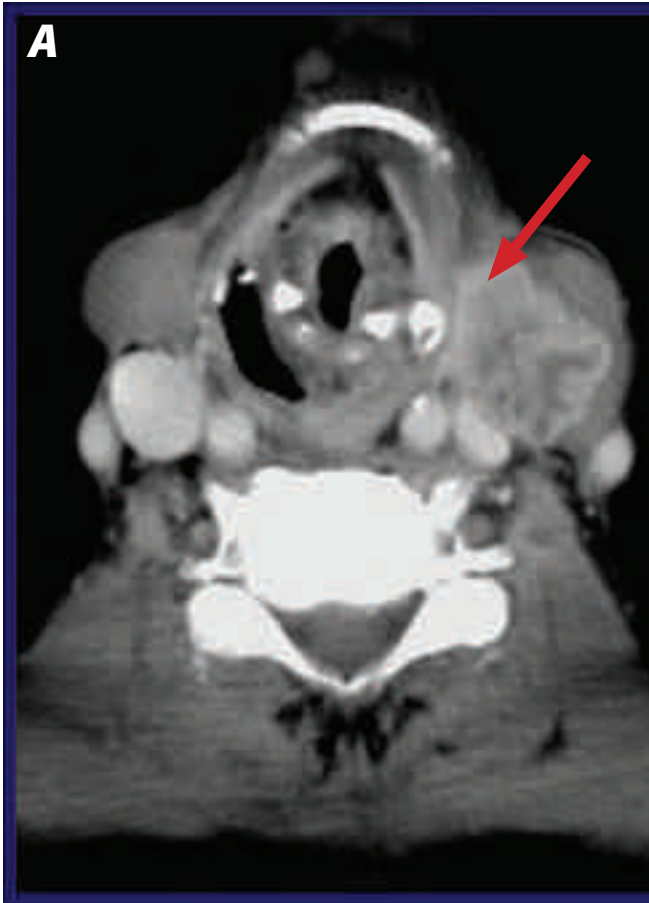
CT scans showing the result of combined chemoradiotherapy and herpes viral gene therapy in a patient with an advanced head and neck cancer. (A) The red arrow in the pre-treatment image shows a large lymph node containing metastatic cancer. (B) This node resolved completely after treatment.
